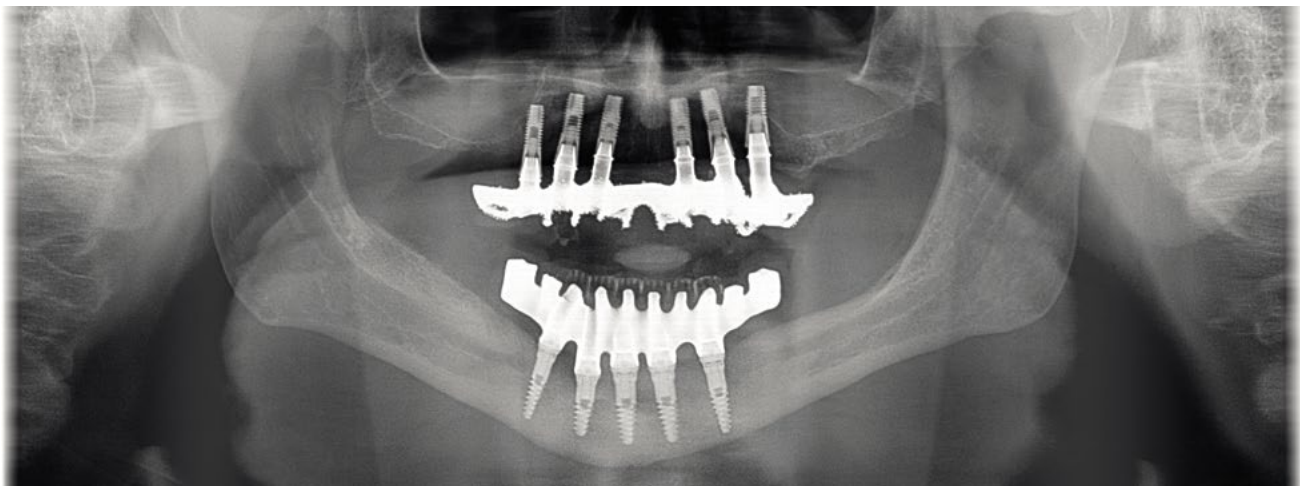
Initial orthopantomography.
